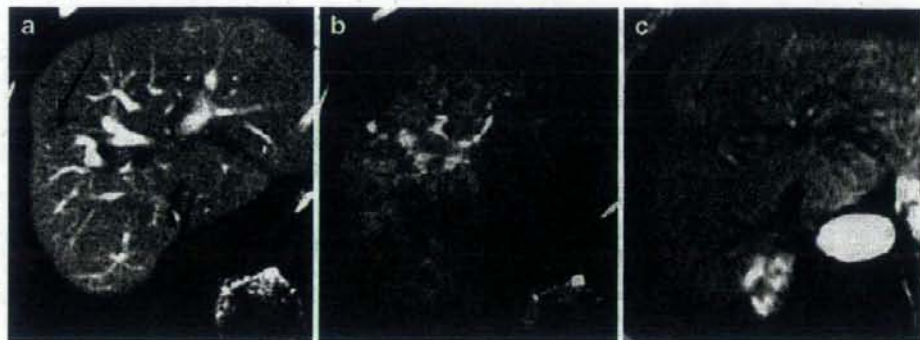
A 63-year-old woman with liver cirrhosis a. Transverse CTAP shows a spotty hypoattenuating area within an isoattenuating nodule in liver segment VIII. b Transverse CTHA shows a spotty hyperattenuating area within a hypoattenuating nodule. c Transverse on the arterial dominant phase of gadolinium-enhanced dynamic MR image shows a hyperintense focus within an isointense nodule
